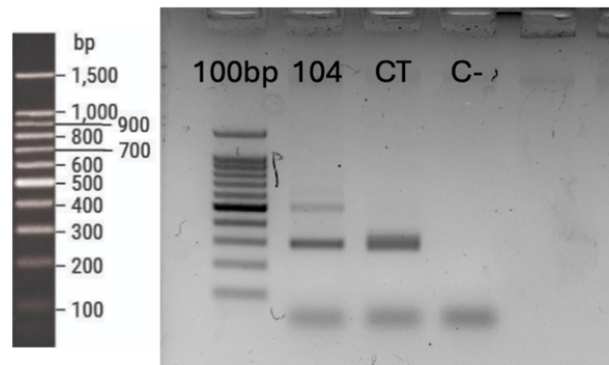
Conventional flanking PCR analysis of *CRACR2A*: Agarose gel electrophoresis of PCR products obtained from patient #104, a control sample and a negative control. Patient #104 showed two amplification products of approximately 300 bp and 500 bp. The control sample showed two amplification products of approximately 280-310 bp; CT, control sample; C-, negative control; 100bp, 100 bp DNA ladder (Promega).
